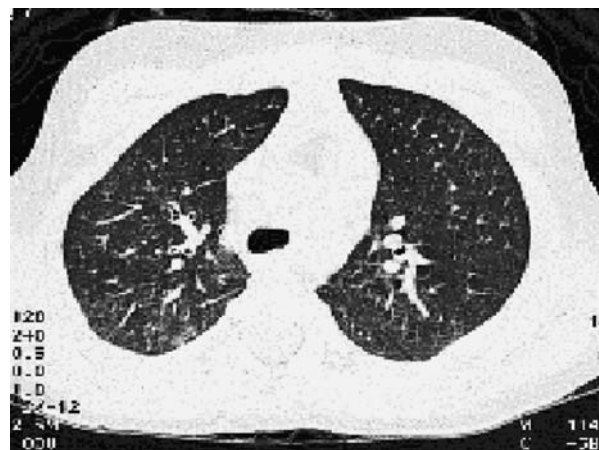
Chest CT scan with mild abnormalities.
